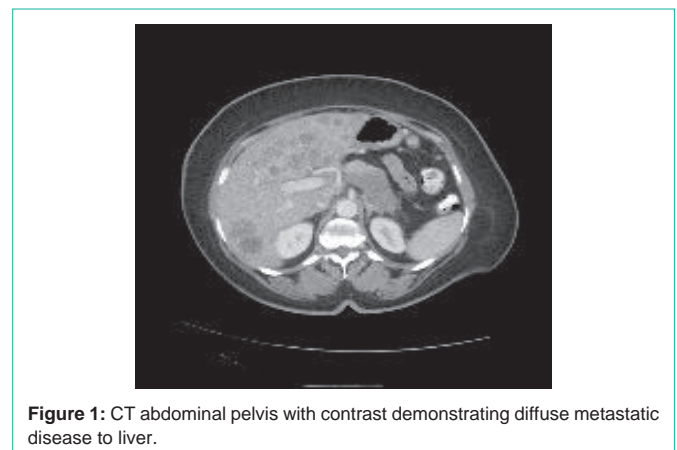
CT abdominal pelvis with contrast demonstrating diffuse metastatic disease to liver.
